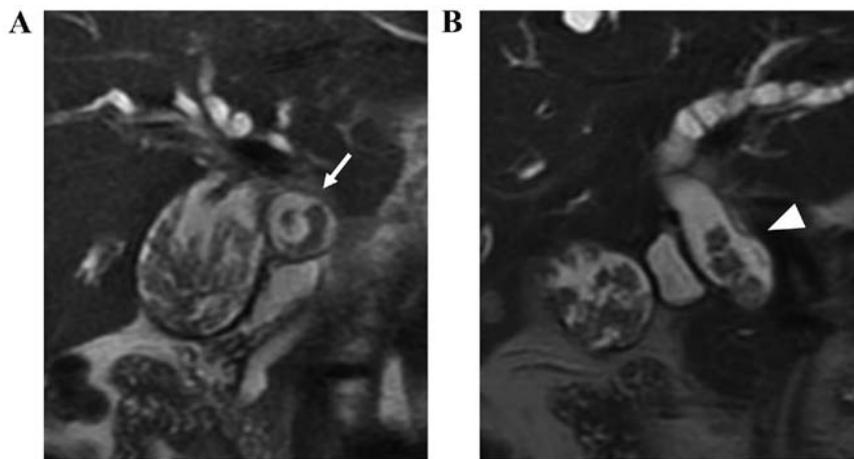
Findings of T2-weighted MRI. (A) T2-weighted MRI (coronal image) showed the papillary tumors filling the gallbladder and spreading to the cystic duct (arrow). (B) The tumors protruded into the common bile duct (arrow head). MRI, magnetic resonance imaging.
